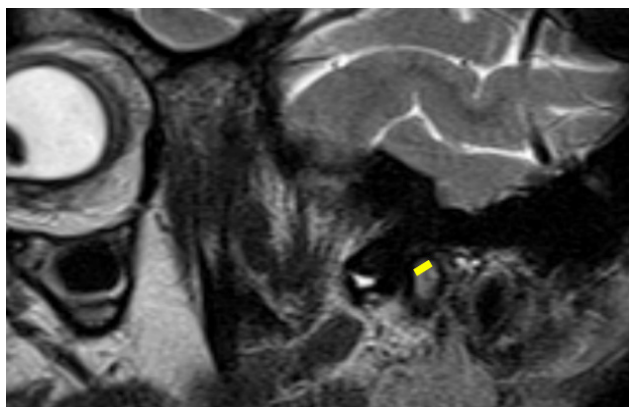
Magnetic resonance imaging of the temporomandibular joint: condylar fracture (line).
